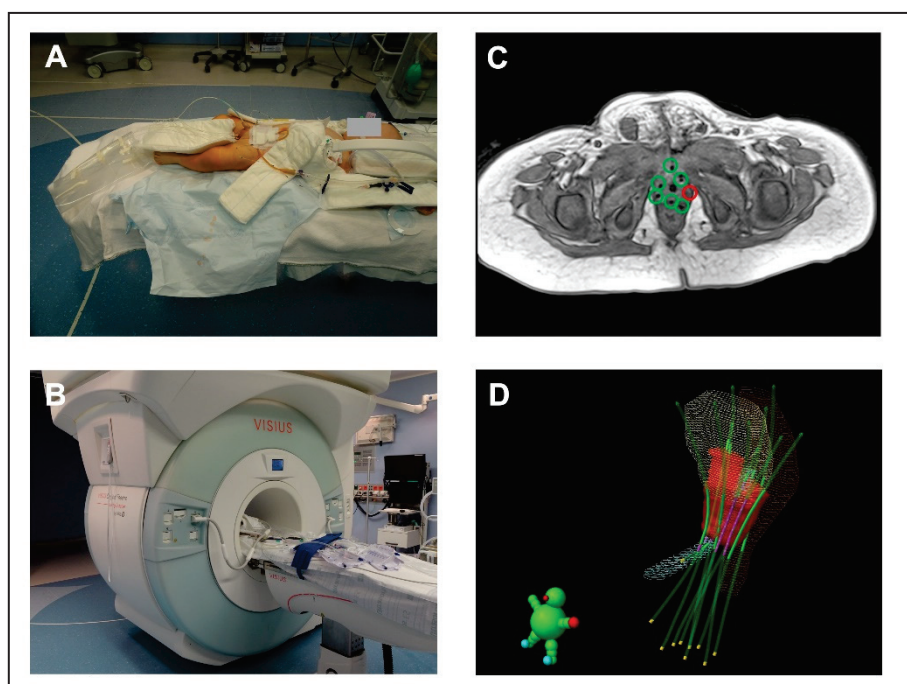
Principle of intraoperative MRI. (A) iMRI suite; position of a child on the table extension designed for this specific purpose. (B) “scanning position” of the magnet. (C) iMR image with BT tubes. The green marked tubes are in the correct position; a tube is missing at the red marked site. (D) 3D image of the BT tube location in relation to the surrounding anatomical structures in the radiotherapy planning system. Red volume = target volume, blue volume = urethra, yellow volume = urinary bladder, brown volume = rectum, green lines = BT tubes.
